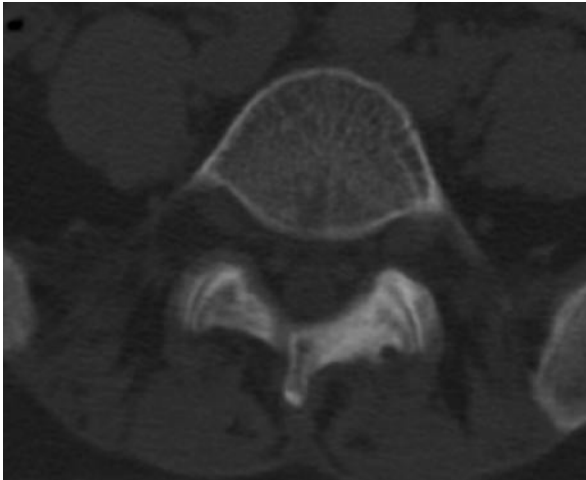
Computed tomography shows sclerosis in facet and hemilamina of L5 vertebra on left side.
